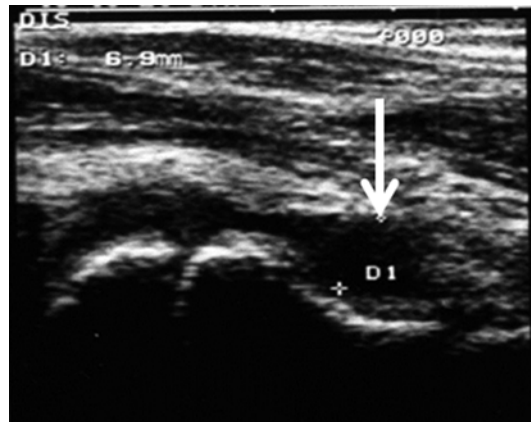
Ultrasound of hip. The capsule (*arrow*) is distended anteriorly by an effusion
